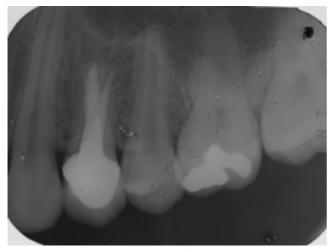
Two-year postoperative radiograph showing complete healing.
